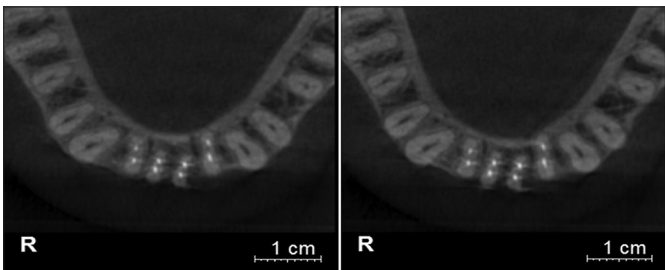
Cone beam computed tomography showing two obturated canals in all the mandibular incisors.
